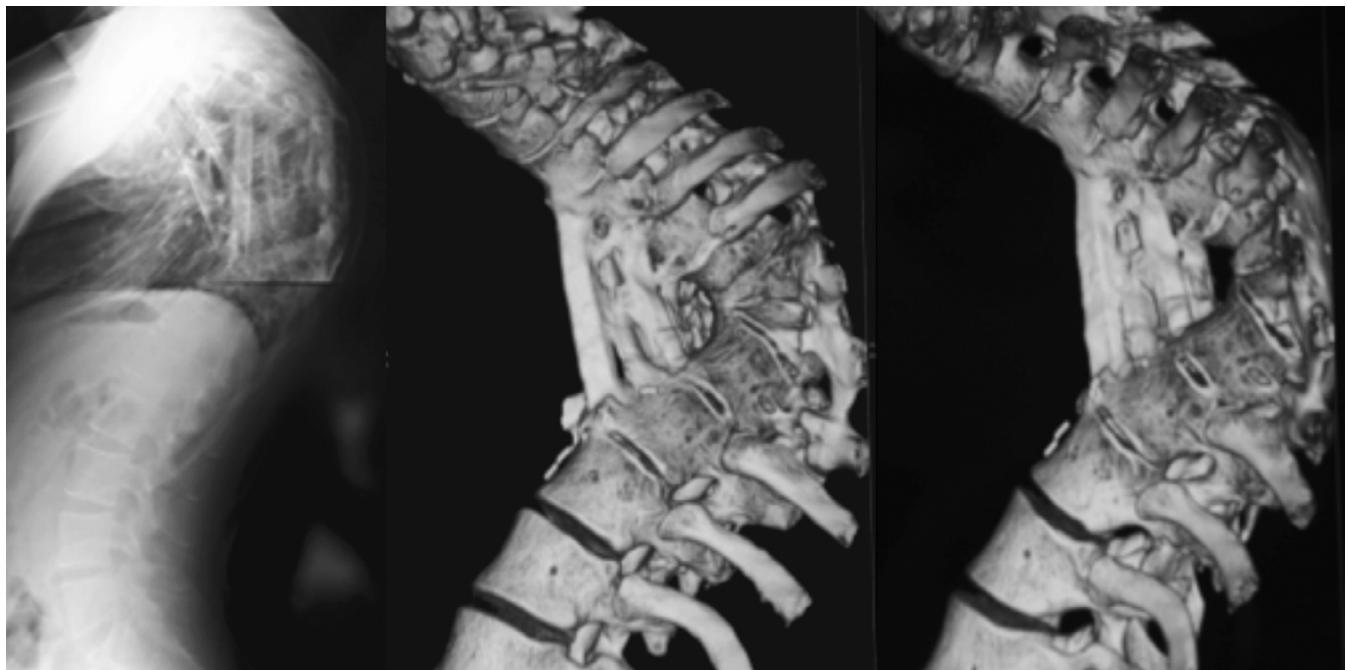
Profile X-ray (Left) and 3-D thoracic spine CT scan reconstructions (Middle and Right) confirmed that the kyphoscoliosis apex was completely merged.
